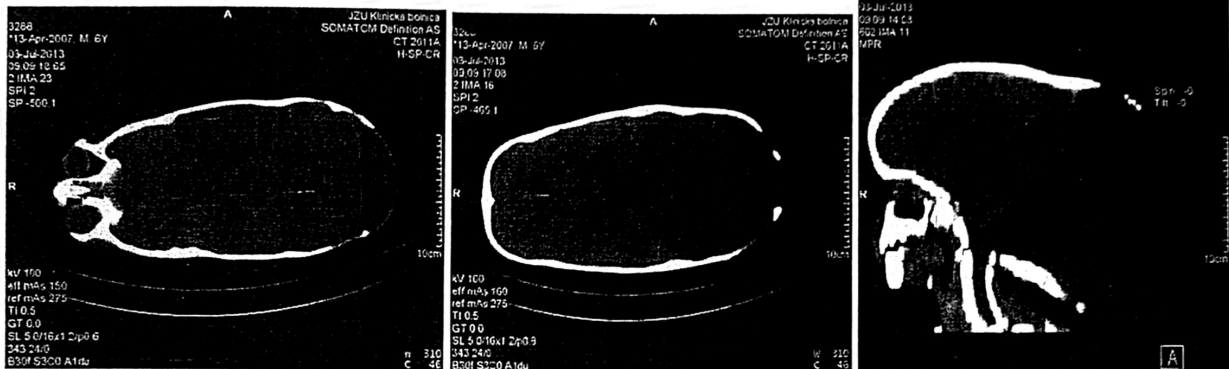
Preoperative CT scan of the boy's head before treatment
